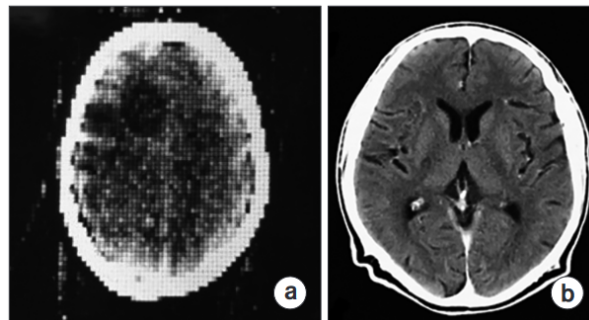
First clinical CT image (80×80 image matrix obtained from the Atkinson Morley Hospital, London, UK) of the brain acquired in 1971 (a). Brain CT image acquired recently (512×512 image matrix, Siemens SOMATOM Plus 4 [Siemens medical systems, Erlangen, Germany]) with a more advanced CT scanner (b). [41]
